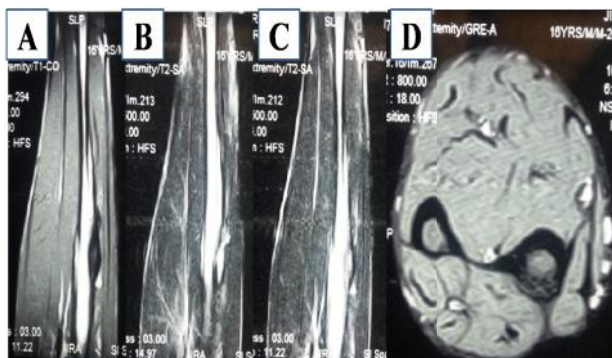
T1 weighted image 2B,C: T2 weighted image 2C: Cross section MRI image showing altered marrow signal intensity in upper shaft of radius with cortical thickening with a tiny dead bone piece seen within the cortical thickening.
